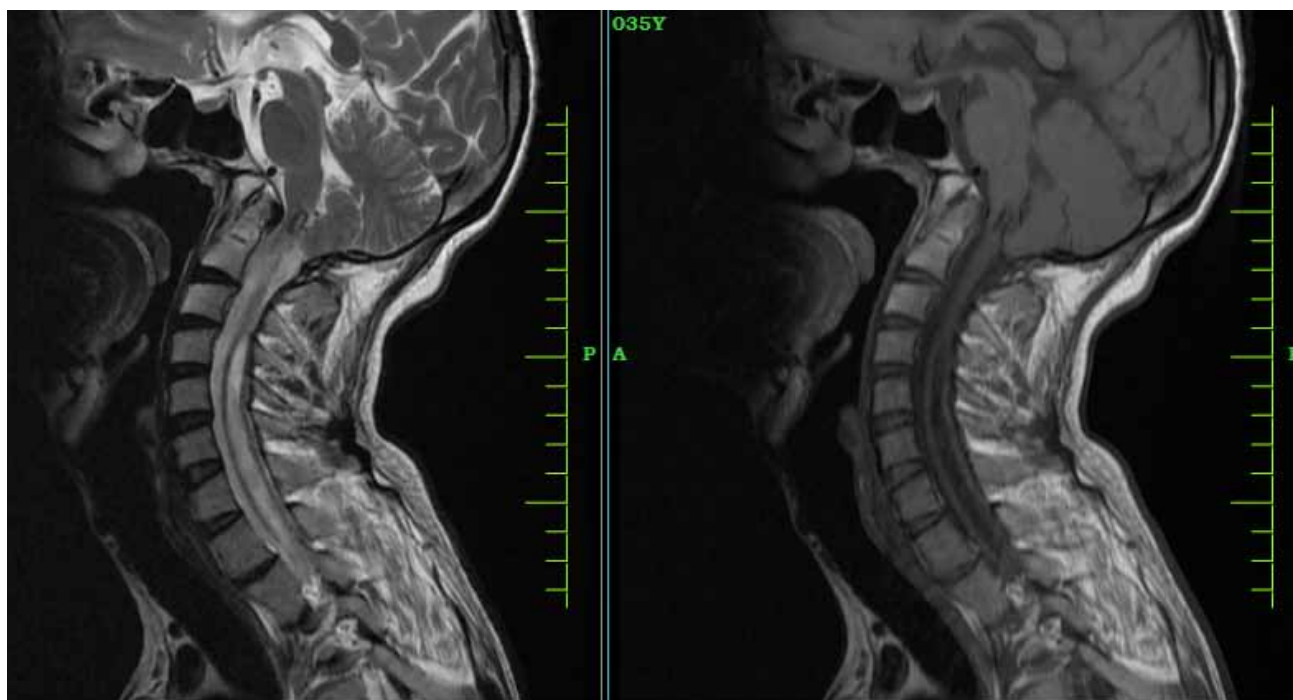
& 4 showing T2 and T1 weighted images of MRI showing a syrinx from the level of C1 vertebra to C2 vertebra. Sagittal section of T2 weighted image was suggestive of Chiari malformation with tonsillar herniation in the spinal canal.
